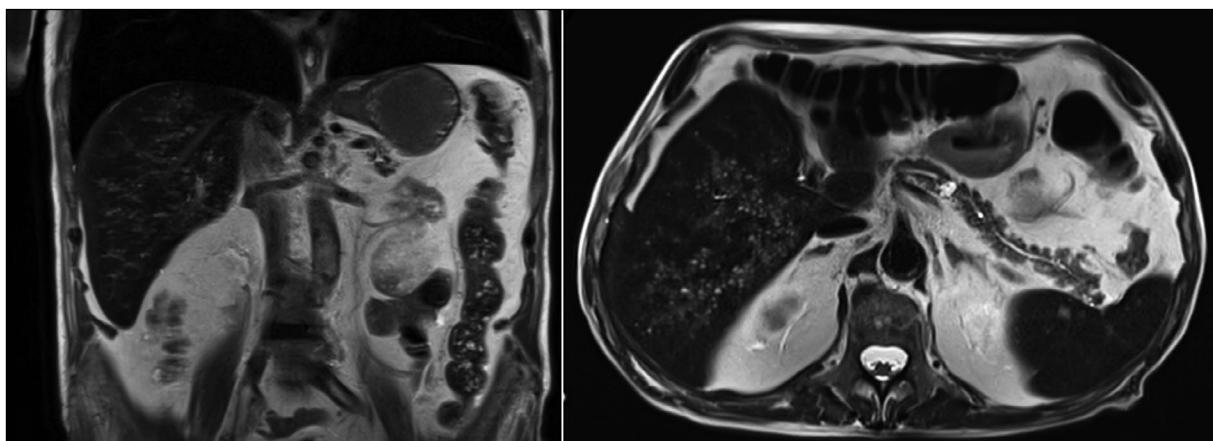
Coronal and axial MRI images with HASTE T2 sequence: multiple small hyperintense lesions throughout the hepatic area.
